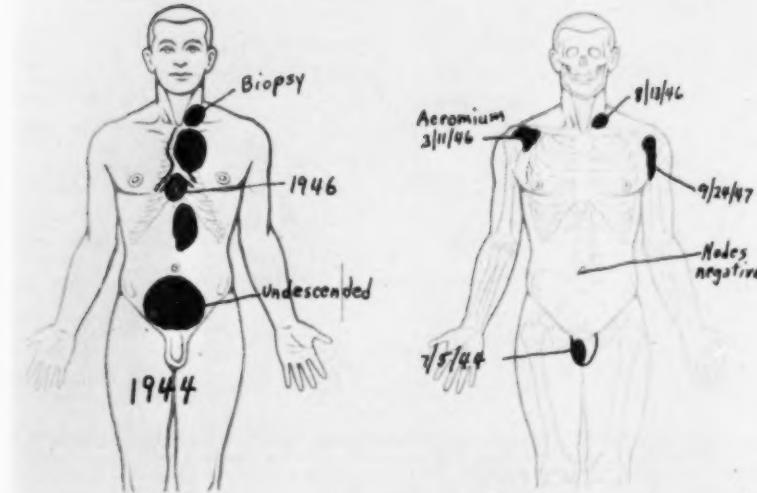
Two patients with widespread seminoma irradiated with 1,000-kv x-rays and free of disease for twelve years since the institution of treatment. The patient on the left had a primary tumor in an undescended testis in the pelvis. The patient on the right had blood-borne metastases in two bones.
